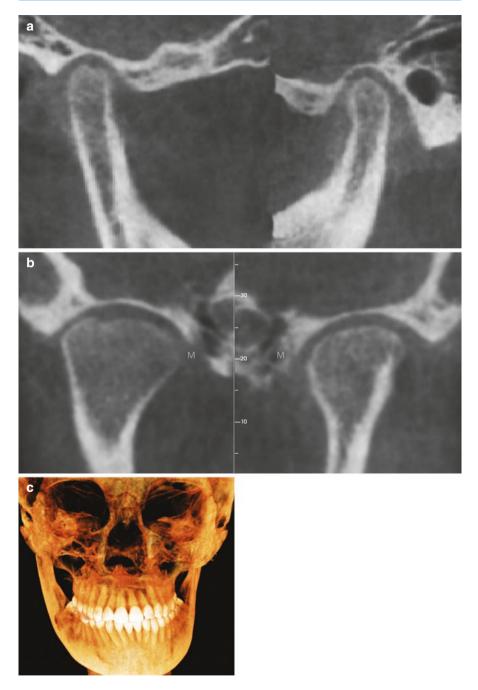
CBCT reformations in a patient with condylar hyperplasia show increase in size of the right condyle with preservation of the position of the condylar contours. The condylar neck is elongated (\mathbf{a} and \mathbf{b}), and the mandible on the right side is larger with deviation of the mandible to the unaffected side (\mathbf{c}) (Courtesy, S. Brooks, DDS)
